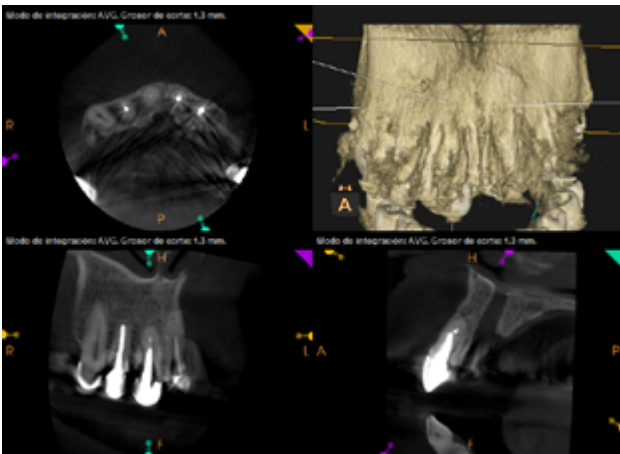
Tomographic image to check at level 11, 18 months after the periapical microsurgery in which the resolution of the preexisting radiolucent periapical lesion can be seen.
